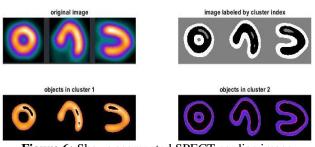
Shows segmented SPECT cardiac image
